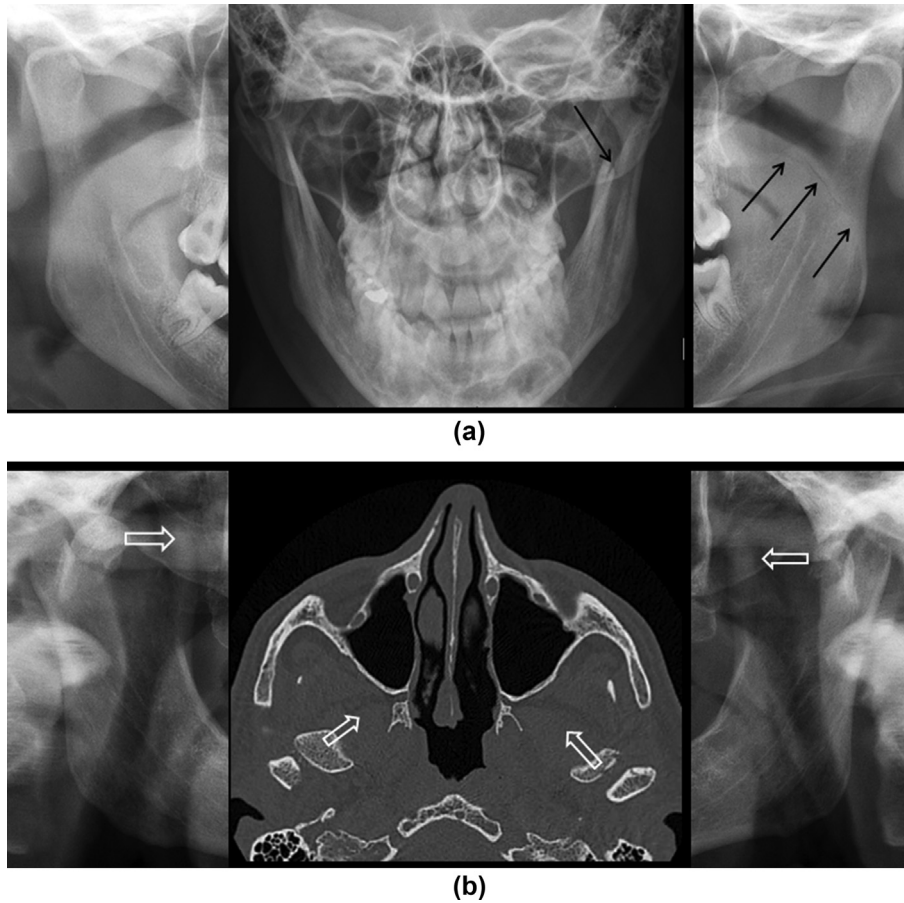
Condylar fractures. (a) There is an undisplaced, low left condylar neck fracture (black arrows), which is shown on cropped images of the condyles and rami from DPT and a central posteroanterior radiograph. (b) Cropped images of the rami and condyles from DPT and central axial bone-window axial MDCT demonstrate bilateral high condylar neck/head fractures. The fragments attached to the lateral pterygoid muscles are displaced anteromedially by the action of these muscles (white open arrows). MDCT is essential for surgical planning; in older patients, these fractures are often treated conservatively.
